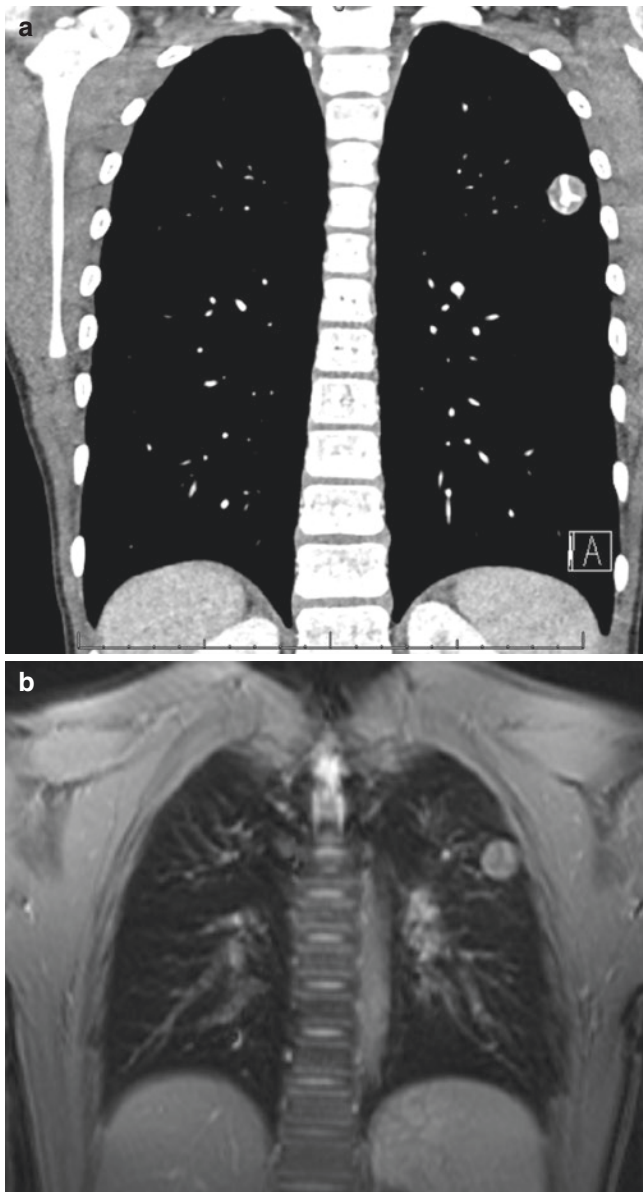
A 9-year-old boy with histoplasmosis. (a) Coronal contrast-enhanced CT image in soft tissue window setting shows a round nodule within the left upper lobe with central calcification. (b) Coronal contrast-enhanced LAVA MR image shows the left upper lobe nodule with a hypointense non-enhancing central portion at the site of calcification
